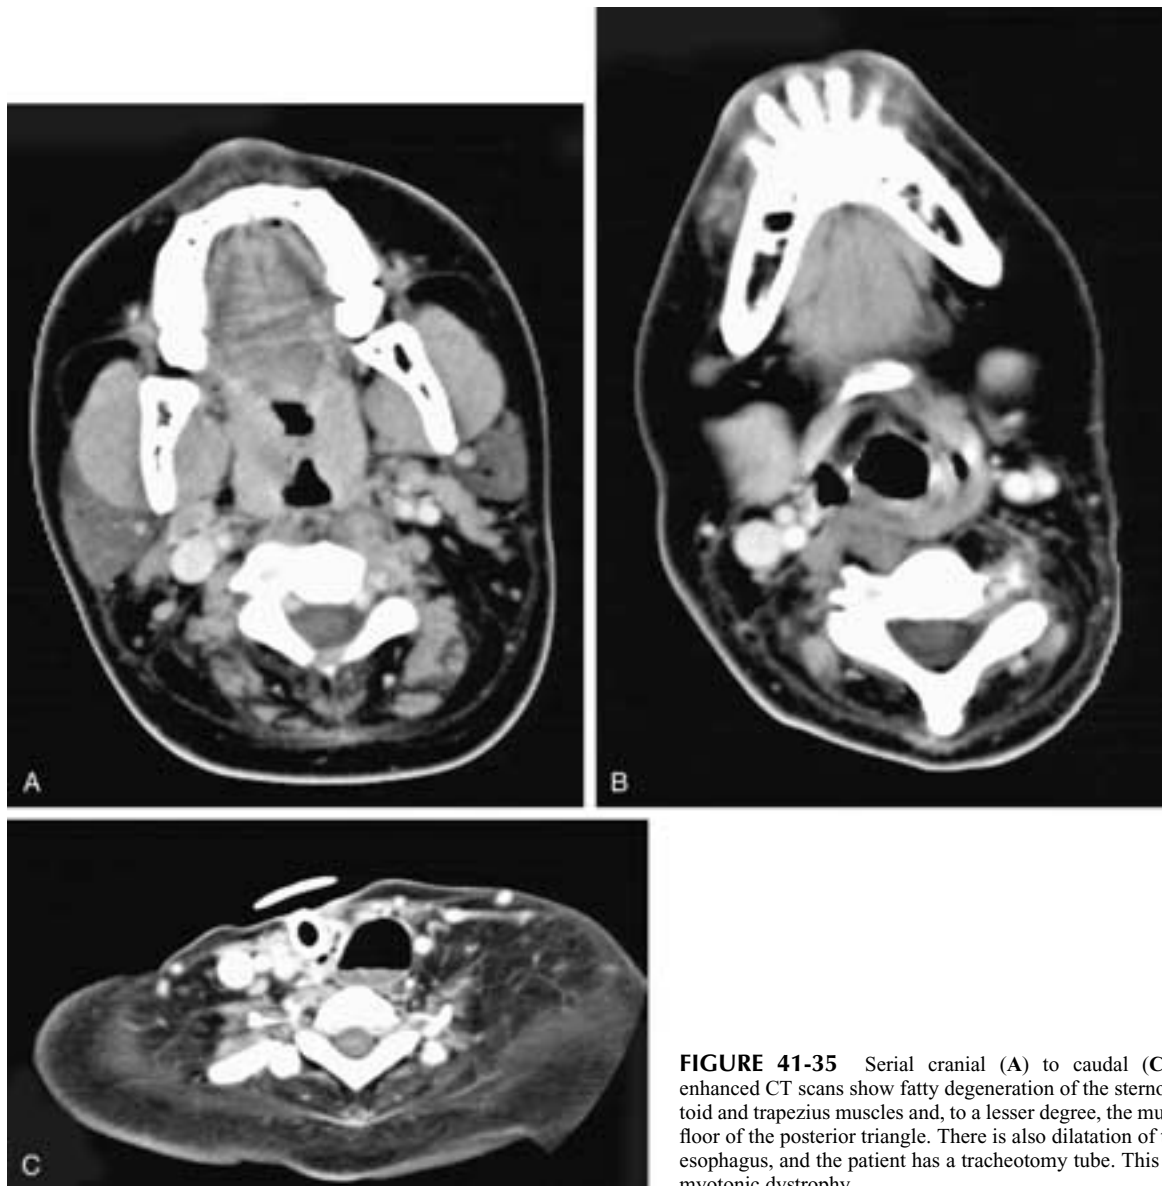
Serial cranial (A) to caudal (C) contrast-enhanced CT scans show fatty degeneration of the sternocleidomastoid and trapezius muscles and, to a lesser degree, the muscles of the floor of the posterior triangle. There is also dilatation of the cervical esophagus, and the patient has a tracheotomy tube. This patient had myotonic dystrophy.
